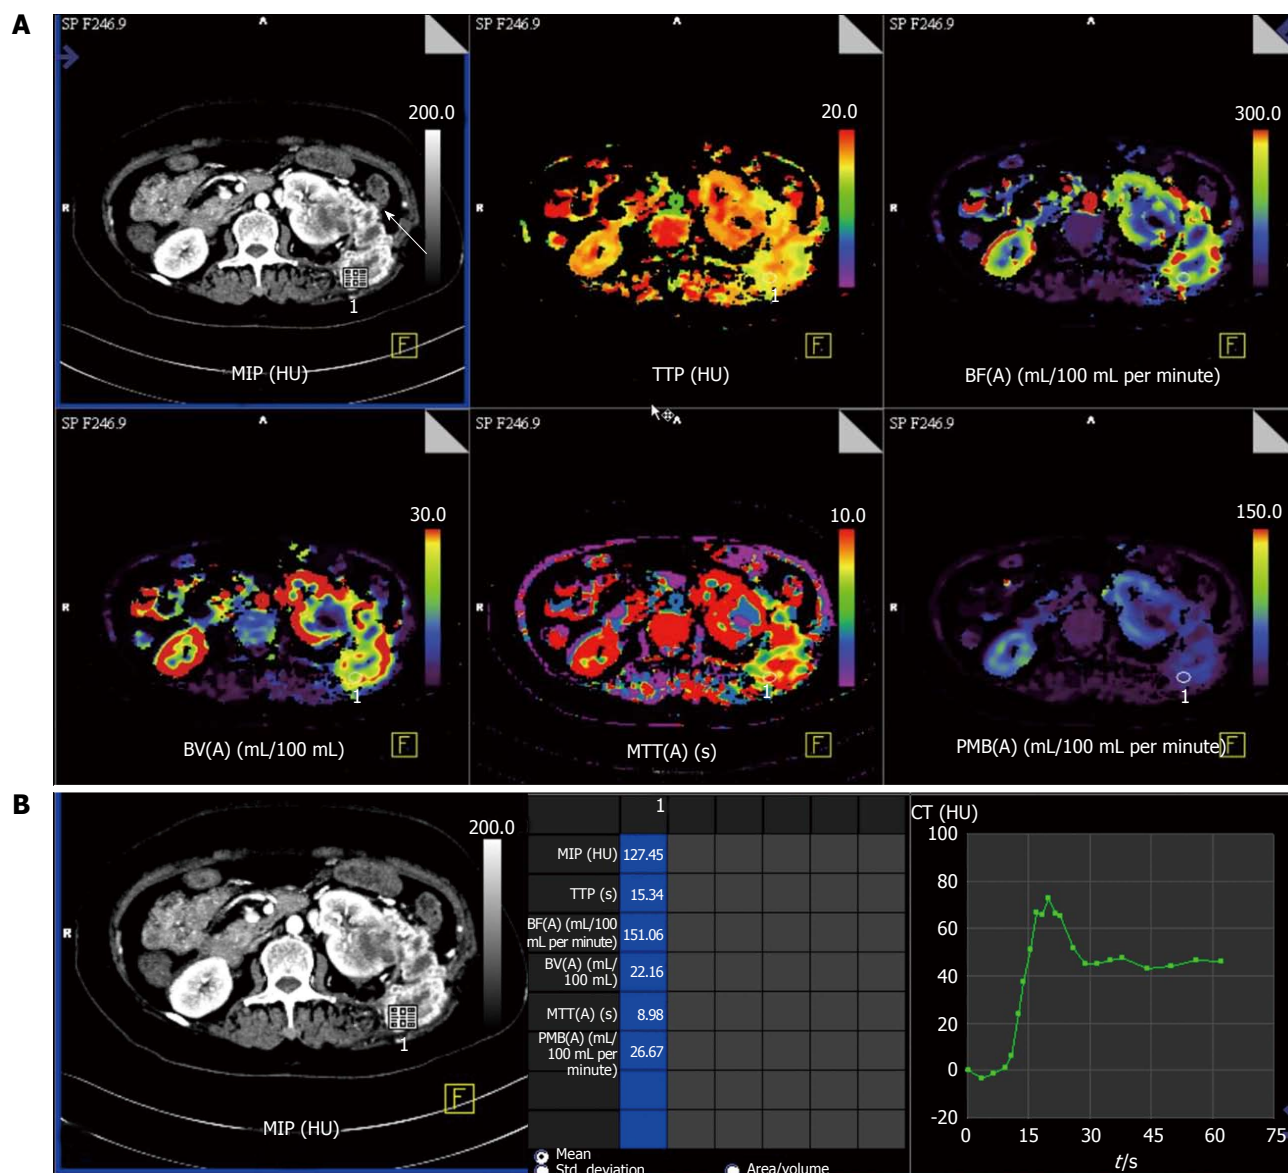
Perfusion computed tomography in a 55-year-old lady with metastatic left renal cell carcinoma. A: Contrast computed tomography (CT) images show heterogeneous necrotic mass in left kidney with abdominal wall metastatic deposit in left lumbar region (arrow) and colour-coded perfusion maps show the perfusion parameters; B: Time attenuation curve and perfusion parameters with region-of-interest placed in the metastatic left lumbar lesion depict delayed wash-out of contrast from the tumour deposit. MIP: Maximum peak intensity; TTP: Time to peak; BF: Blood flow; BV: Blood volume; MTT: Mean transit time; PMB: Permeability.
